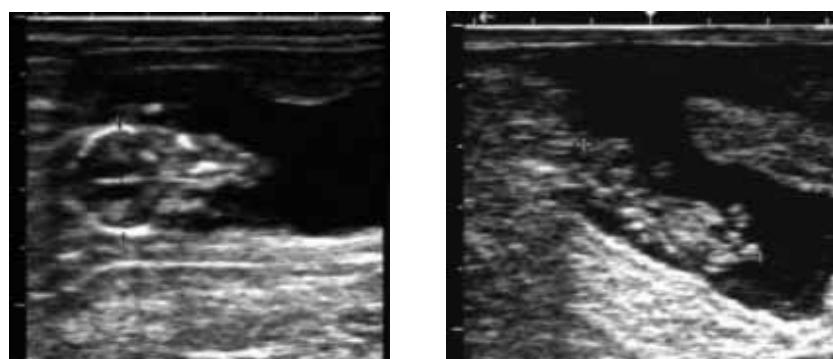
Determination of buffalo foetal head (left panel) and crown rump length (right panel) by ultrasound.
